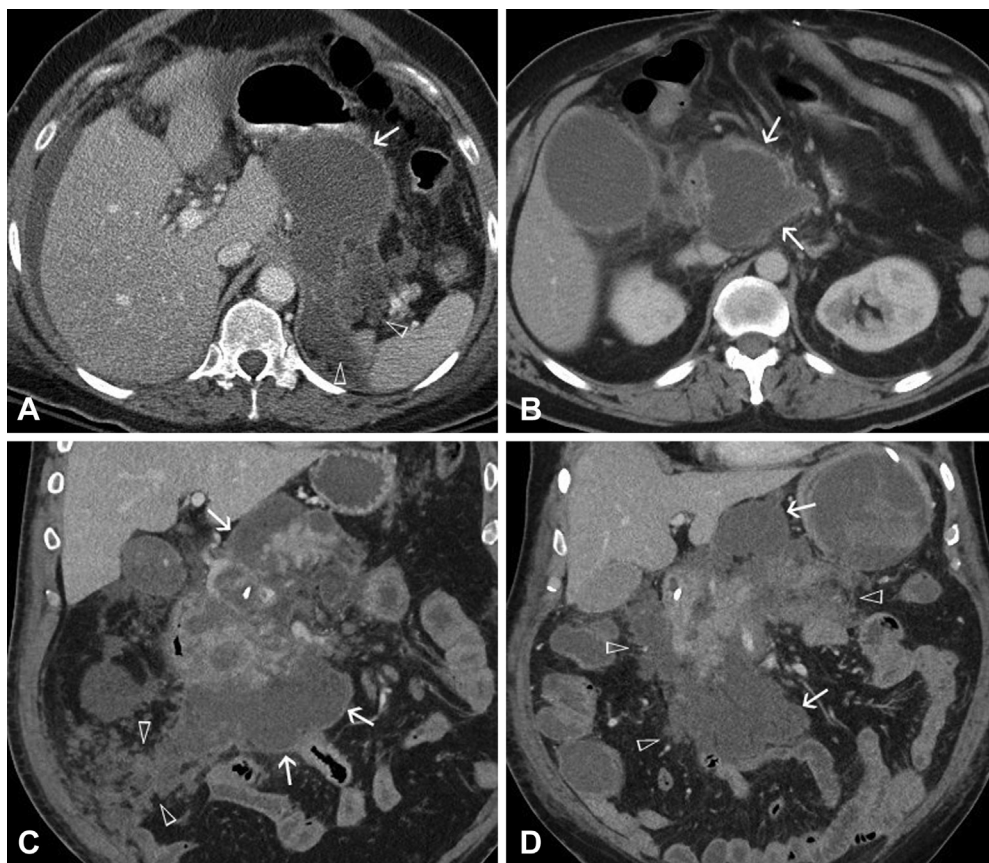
Contrast-enhanced CT scans of acute necrotic collections that underwent endoscopic intervention. *Arrows* indicate portions of the collection with a wall, and *arrowheads* indicate portions of the collection without a wall. A, Thick partial wall. B, Thick complete wall. C, Thick partial wall. D, Thin partial wall.
